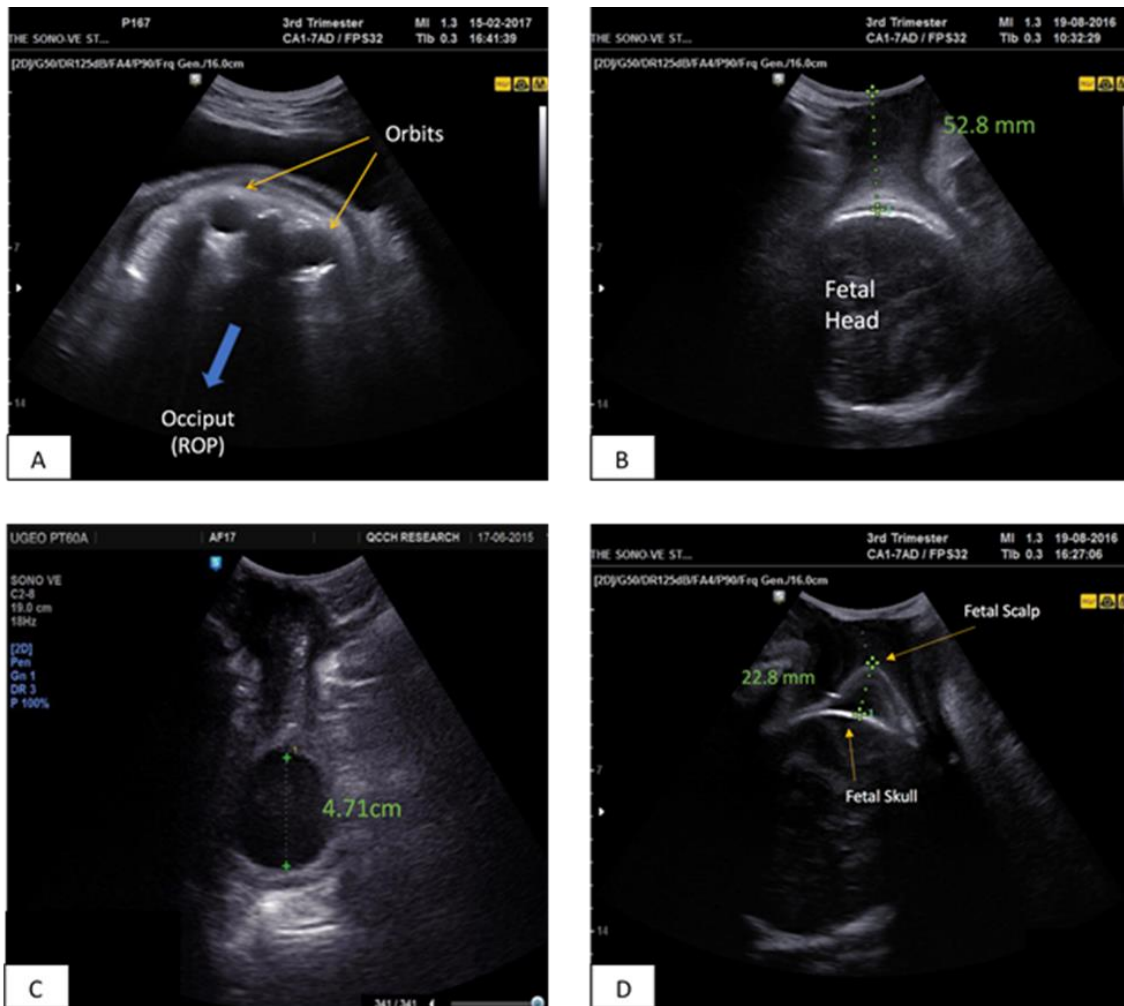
Transabdominal ultrasound was used to determine fetal head position (A), whilst transperineal ultrasound was used to determine Head Perineum Distance (HPD) (B), cervical dilatation (C) and to measure caput succedaneum (D).
